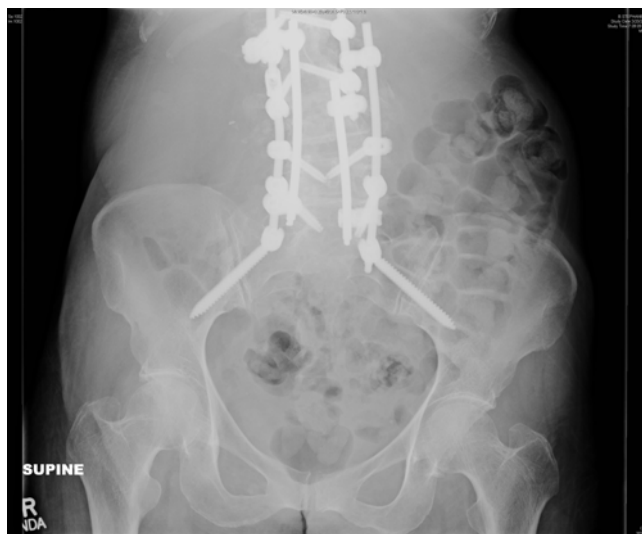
An abdominal radiograph obtained on the third post-operative day demonstrated stool in the colon and no signs of ileus.
